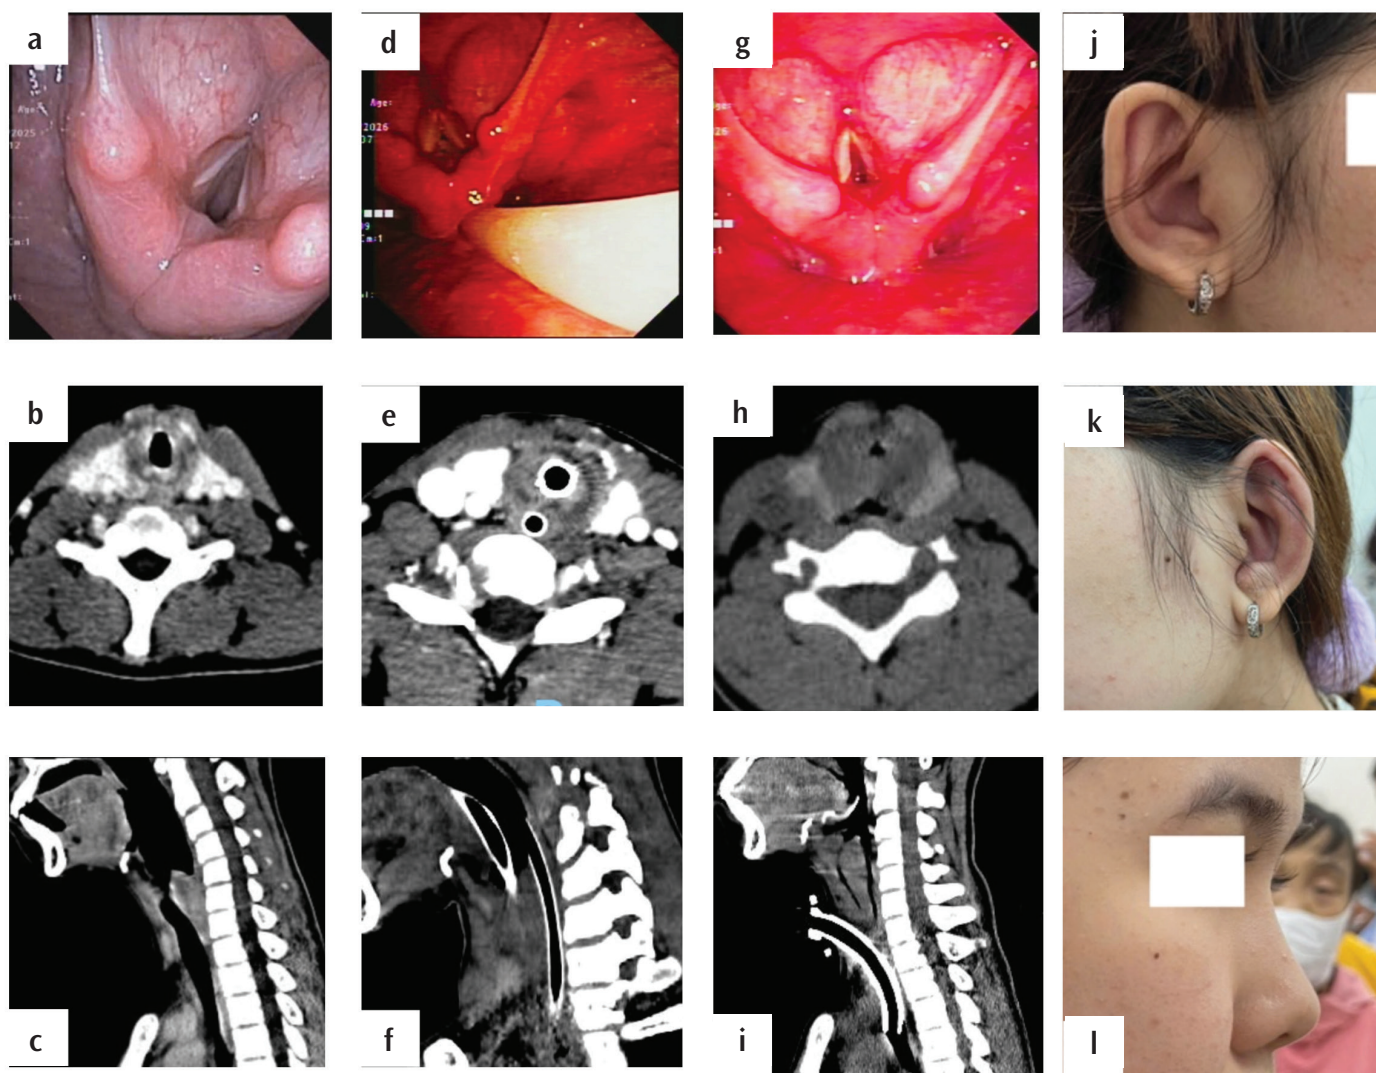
Sequential endoscopic, radiological and clinical findings during the diagnostic course. (a) Initial laryngoscopy at the first hospital showing diffuse vocal fold edema without an apparent tumor. (b, c) Initial neck computed tomography (CT) at the first hospital showing laryngeal wall thickening and marked airway narrowing without an intraluminal mass. (d) Laryngoscopy during the acute airway episode following difficult intubation and tracheostomy, showing severe laryngeal edema and glottic narrowing. (e, f) Neck CT during the same acute episode showing laryngeal wall thickening and airway narrowing. (g) Follow-up laryngoscopy when a subglottic tumor was suspected, showing persistent glottic-subglottic edema and stenosis. (h, i) Neck CT at the tumor-mimic stage showing a supraglottic-subglottic mass-like stenotic lesion. (j, k) Bilateral auricular chondritis detected at rheumatology assessment. (l) Normal nasal cartilage appearance.
